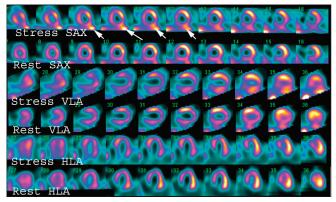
Nondiagnostic myocardial perfusion SPECT in a 59-year-old male who was a liver transplant candidate. Stress images shows extensive extracardiac activity adjacent to the inferior wall of the left ventricle (arrows), a common finding in patients with liver disease due to ascites and bowel activity. The rest of the images show normal myocardial perfusion. To role out coronary artery disease, coronary computed tomography was performed, and showed normal coronary arteries (SAX: short axis, VLA: vertical long axis, HLA: horizontal long axis)
